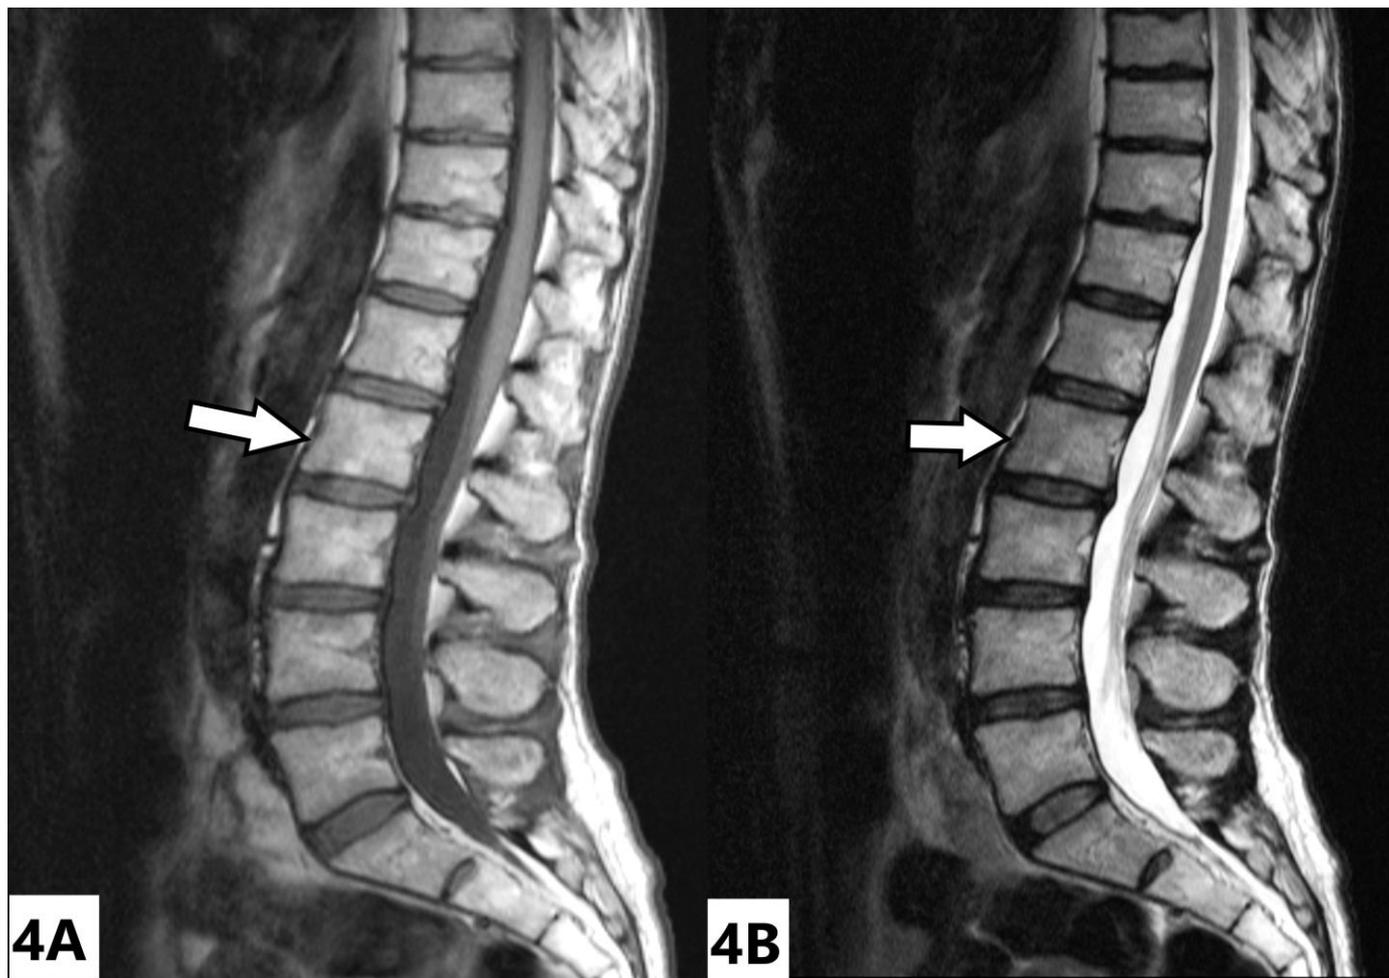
A 66-year-old female with flip-flop phenomenon - MRI pitfall.
